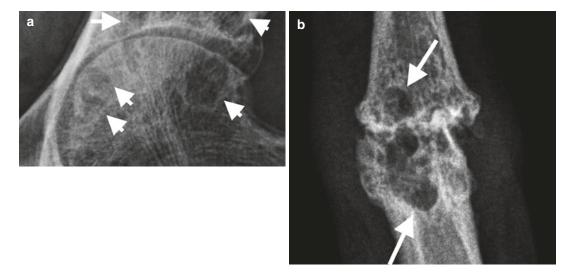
Subchondral cysts (*arrows*) on radiographs, (a) well-defined subchondral lucencies with well-defined sclerotic margins in a degenerative hip joint (normal
